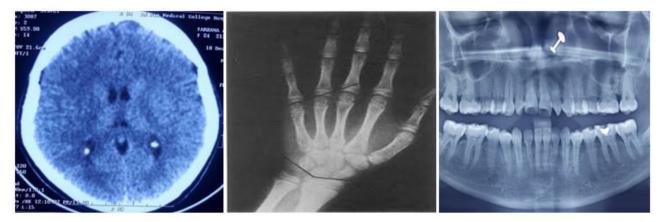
Showing CT brain with bilateral calcification of choroid plexus of posterior horn both lateral ventricles, x-ray hand with short 4th and 5th metacarpals and OPG with hypolastic anterior teeth respectively
